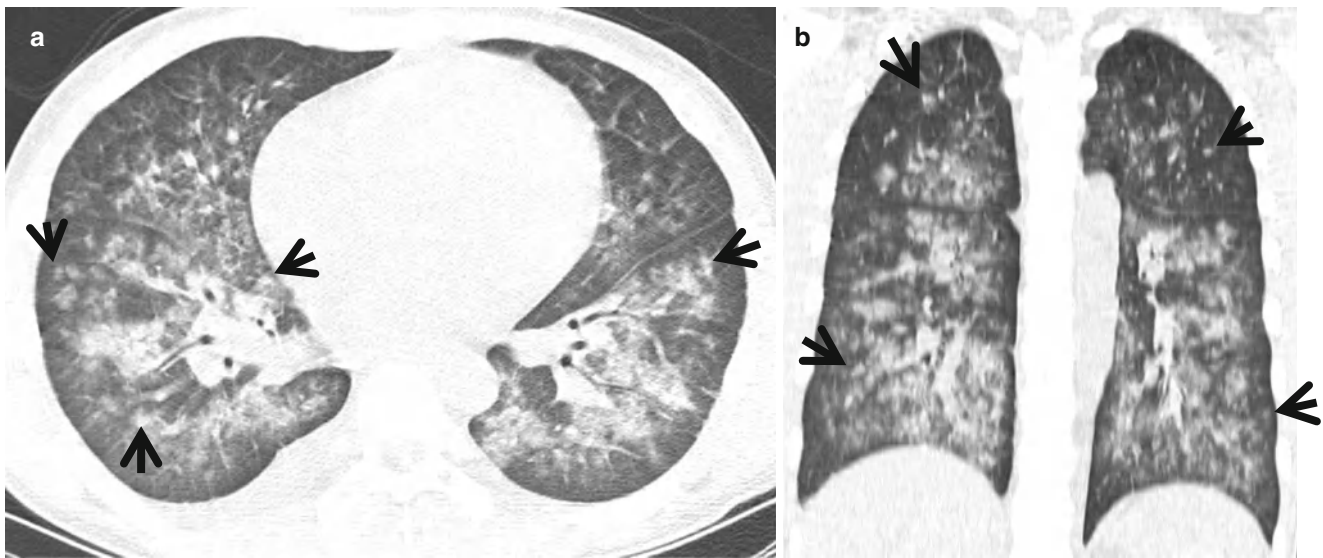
Diffuse alveolar hemorrhage in a 15-year-old boy with IgA nephropathy and pulmonary capillaritis. (a, b) Lung window image of CT (2.5-mm section thickness) scan obtained at level of inferior pulmonary veins shows patchy and extensive parenchymal opacity in both lungs. Please also note small poorly formed centrilobular nodules (*arrows*) in both lungs
